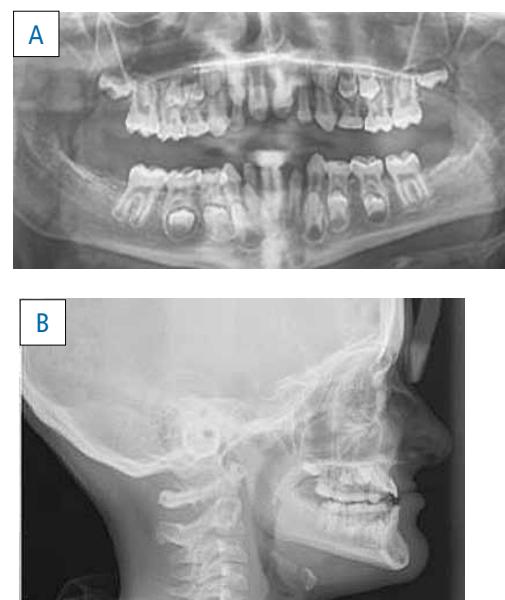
Orthopantomography shows agenesis of teeth 31, 41, 37, 47, 18, 28, 38, 48 (A). The teleradiography shows a skeletal Class III with mandibular protrusion (B).
